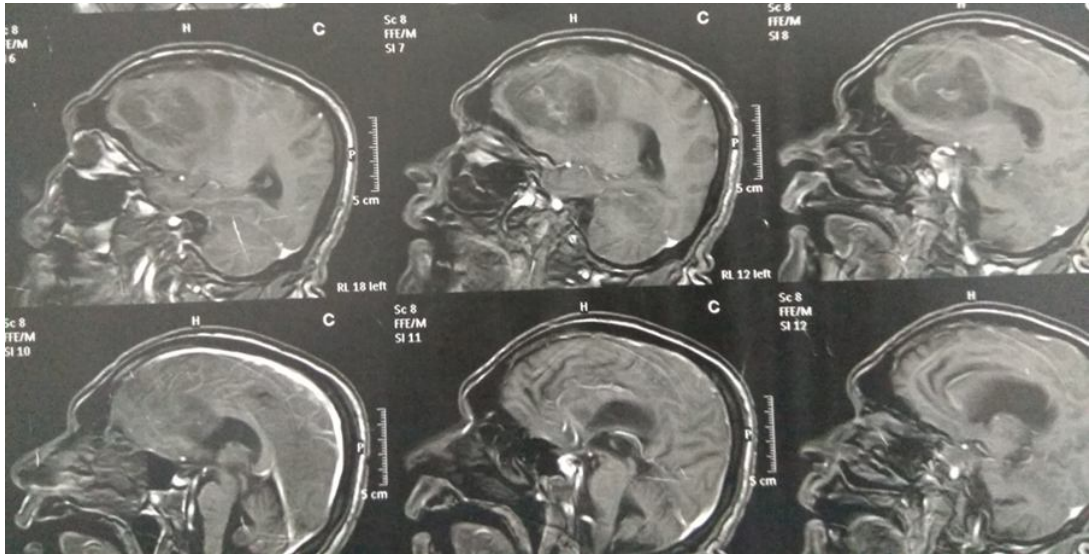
Pre-operative MRI brain with contrast (sagittal view).
